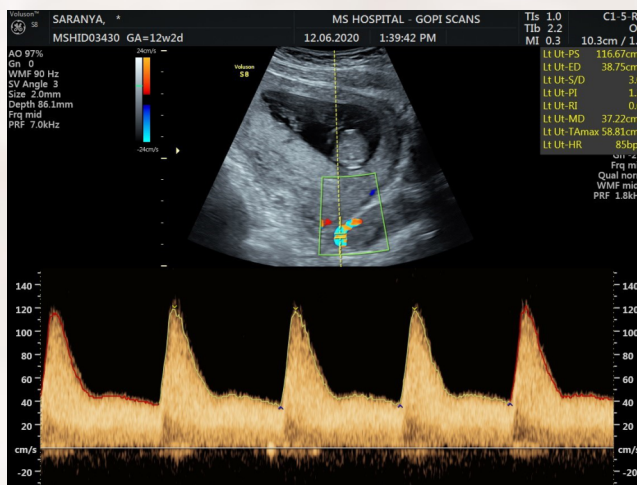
PULSE WAVE DOPPLER OF THE UTERINE ARTERY
